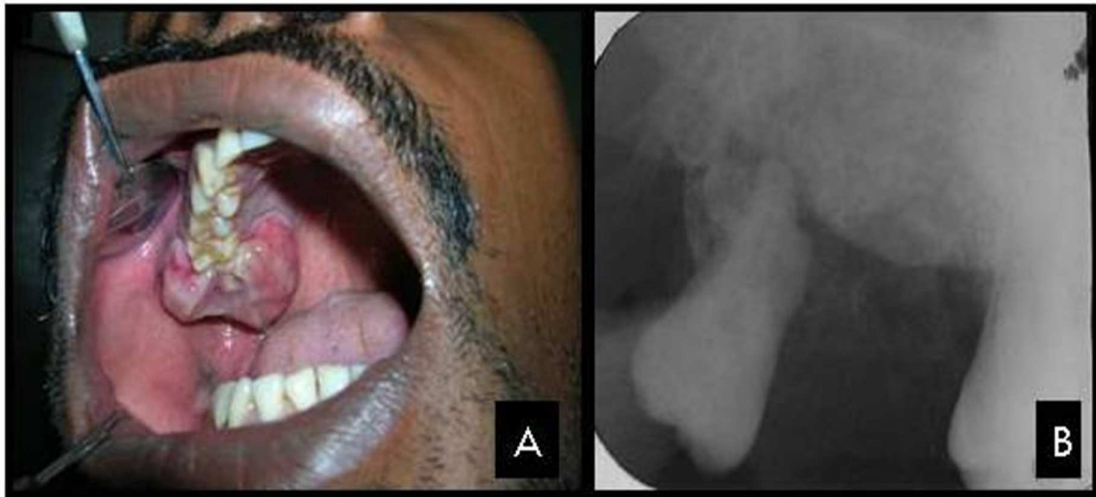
A- Intraoral photograph showing nonulcerated broad based swelling over the right maxillary posterior alveolar ridge, B- IOPA X-Ray showing bone loss.
